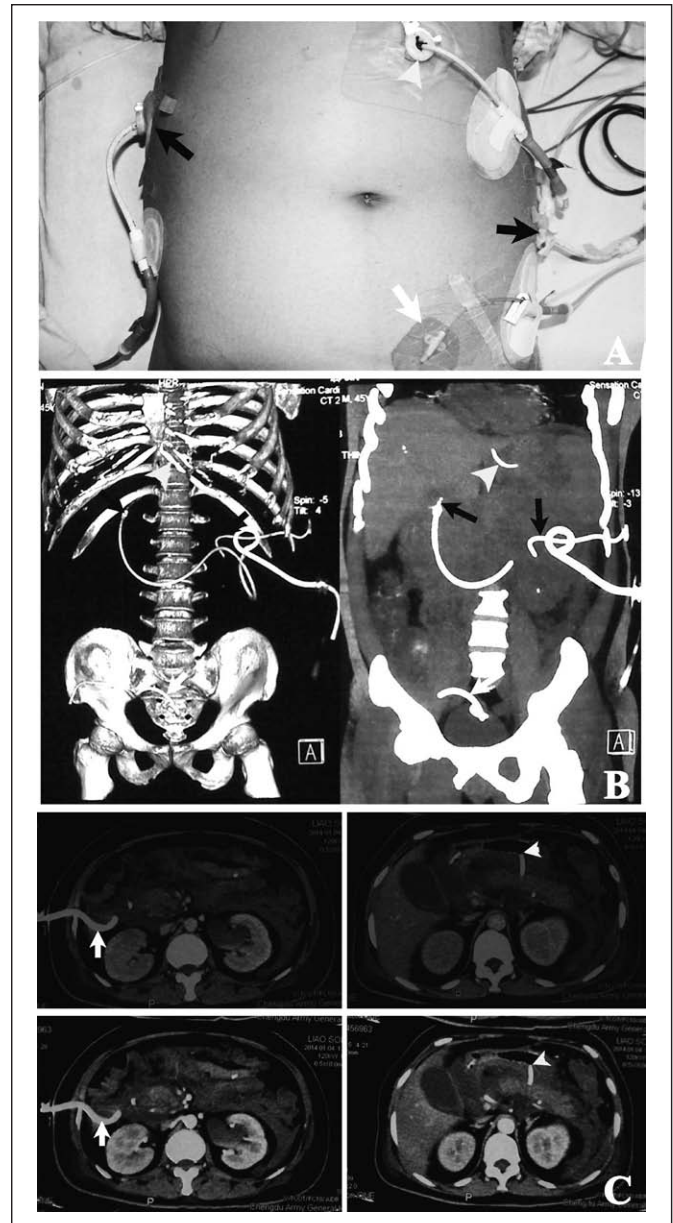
The placement of catheters under abdominal paracentesis drainage (APD) and percutaneous catheter drainage (PCD). In a patient with severe acute pancreatitis, both APD and PCD were used. A and B, Three APDs were as follows: two catheters, respectively, in the left paracolic sulci and right paracolic sulci (RPCS) (for ingress), as shown by *black arrows*; one catheter in the cavitas pelvis (for egress of fluid), displayed by *white arrows*. Meanwhile one PCD was in the (peri)pancreatic region (for egress of fluid), as presented by *white arrows*. C, In CT images, the *white arrows* show catheter in the RPCS by APD insertion done on day 18 of the disease; the *white arrows* show the end of catheter locating in the (peri)pancreatic region with residual collection by PCD intervention performed on day 85 after the onset of pancreatitis.
